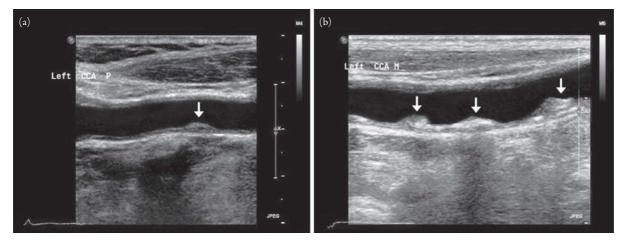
A carotid ultrasound showing carotid plaques in two patients. (a) shows a single asymptomatic plaque which is low risk. The image has an arrow pointing to a smooth, homogenous plaque and (b) shows moderate to large amount of heterogeneous plaques with irregular surfaces. Adapted from Figure 1 of Park TH. Evaluation of carotid plaque using ultrasound imaging. *J Cardiovasc Ultrasound*. 2016;24(2):91–95.
